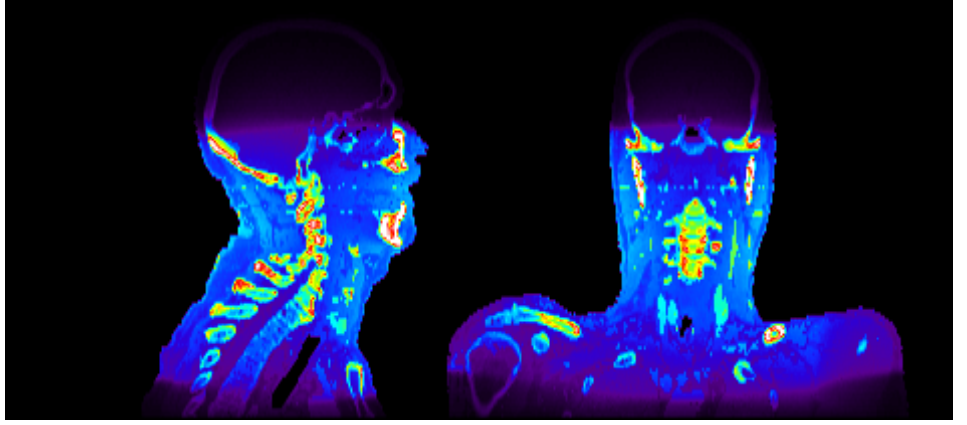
Central slices for Pat. A for a cone beam CT acquisition (360° tube rotation). The slice positions are marked in the CT-slices shown in (n) - (p).
